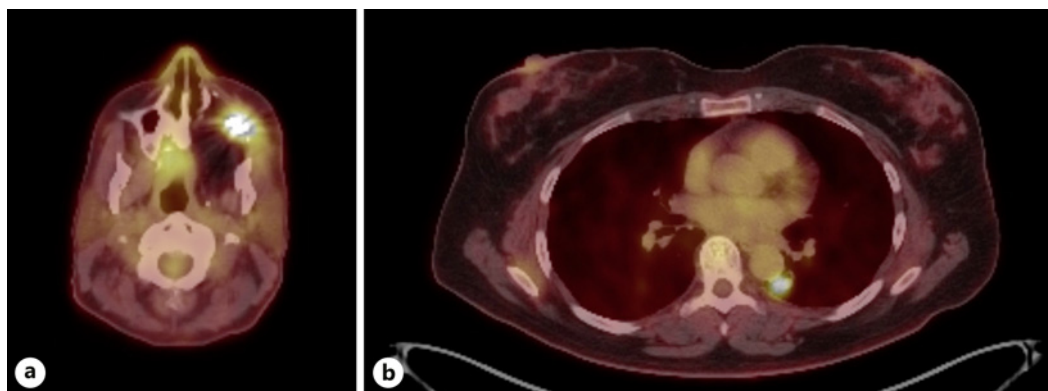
PET scan at time of recurrence. a FDG uptake within the postsurgical bed at the left orbital floor, concerning for recurrence of ameloblastoma. b FDG uptake in the left lower lobe pulmonary nodule posterior to the aorta, suspicious for metastatic disease.
